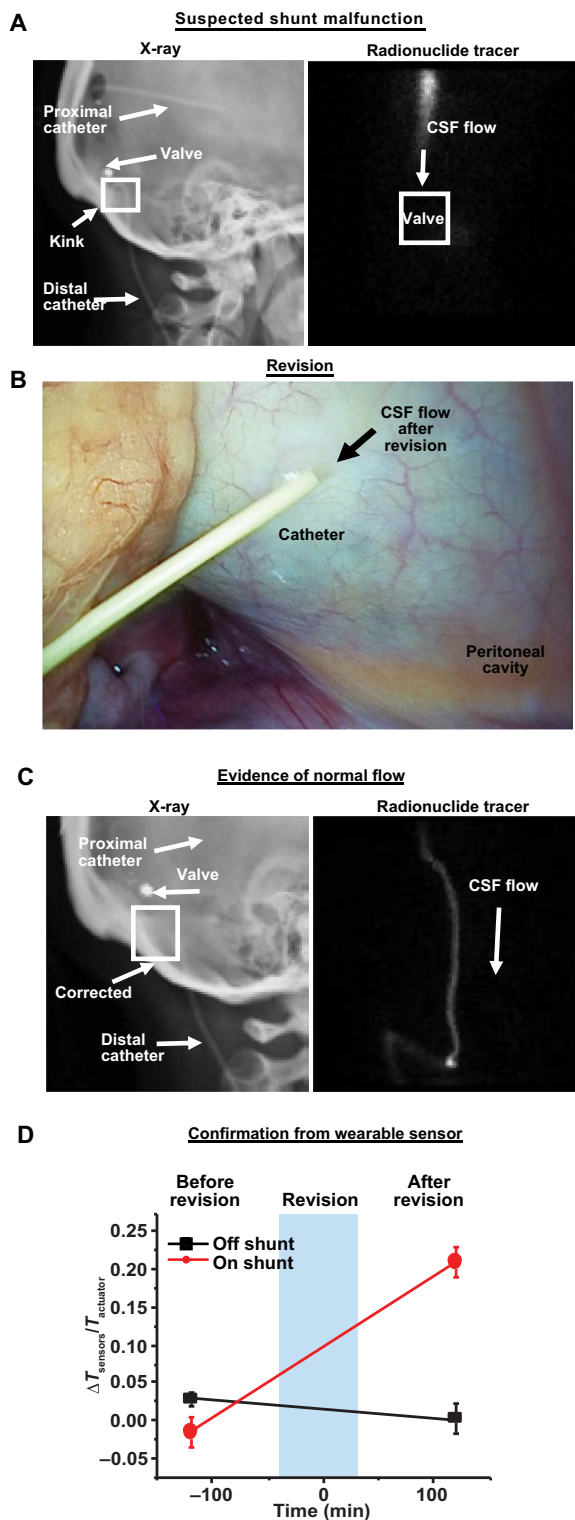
Case study of a patient with hydrocephalus with shunt malfunction. (A) X-ray and radionuclide tracer showing kinking and occlusion of catheter. (B) Optical image of patient's peritoneal cavity immediately after surgery showing flow in repaired shunt. (C) X-ray and radionuclide tracer confirming proper operation of the repaired shunt. (D) $\Delta T_{\text{sensors}}/T_{\text{actuator}}$ measured by ELA at locations over (on) and adjacent to (off) the shunt before and after revision, confirming results from x-ray and radionuclide tracer. Blue shading indicates revision period. All data were collected on a patient ($n = 1$).
